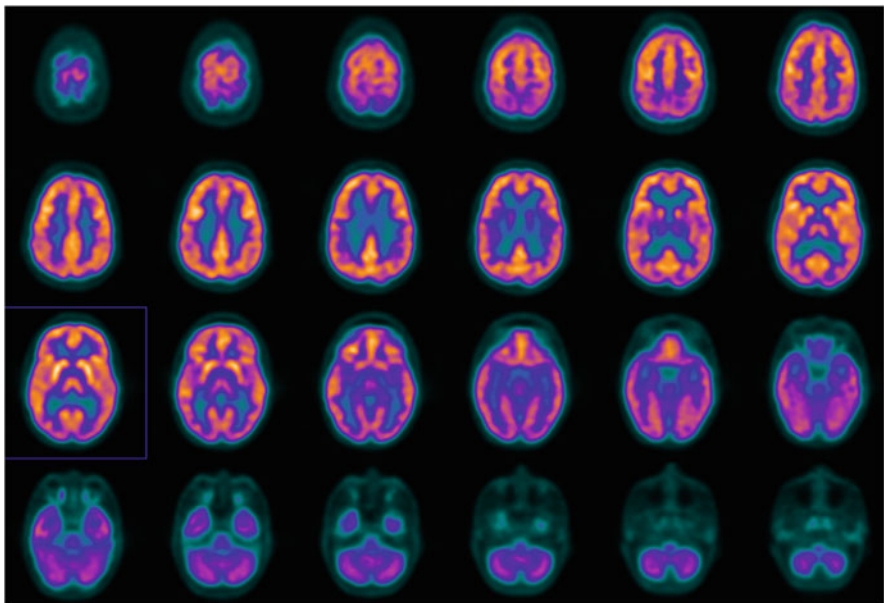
Fluorodeoxyglucose positron emission tomography (FDG-PET)
